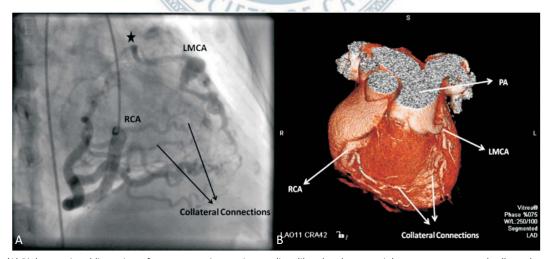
(A) Right anterior oblique view of coronary angiogram is revealing dilated and tortuos right coronary artery and collateral connection between the coronary system. (B) Three dimensional reconstruction of multislice computed tomography is showing that left main coronary artery is originated from the pulmonary artery (star). LMCA, left main coronary artery; PA, pulmonary artery; RCA, right coronary artery.
